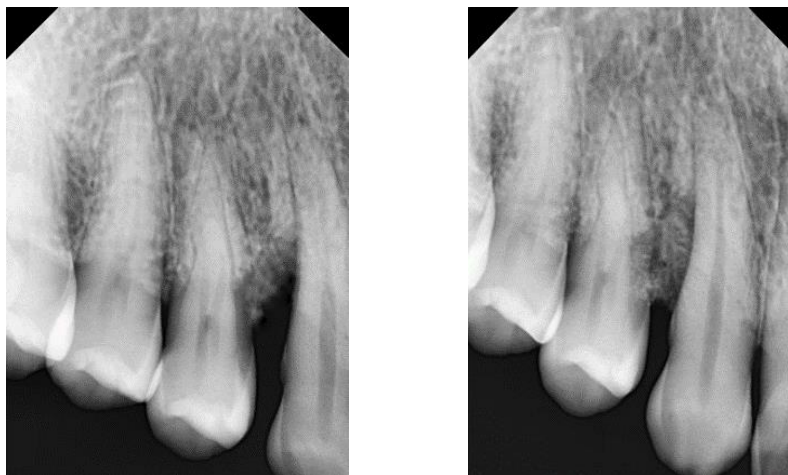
Experimental site A – Pre-operative radiograph
